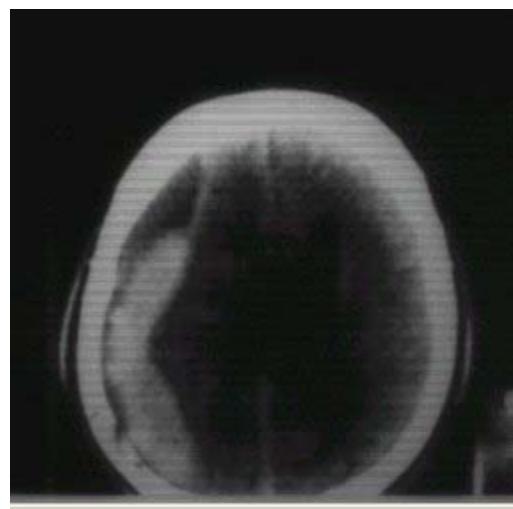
Axial CT. Rt. CSH hyper-dense to the brain
